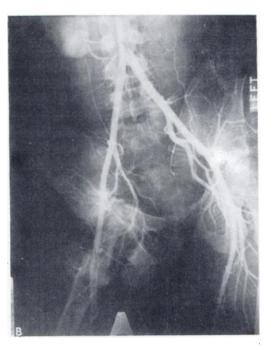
(A) Radiograph of pelvis demonstrates pseudarthrosis of right hip. (B) Arterial phase of normal angiogram (incidentally noted is accessory right renal artery).
